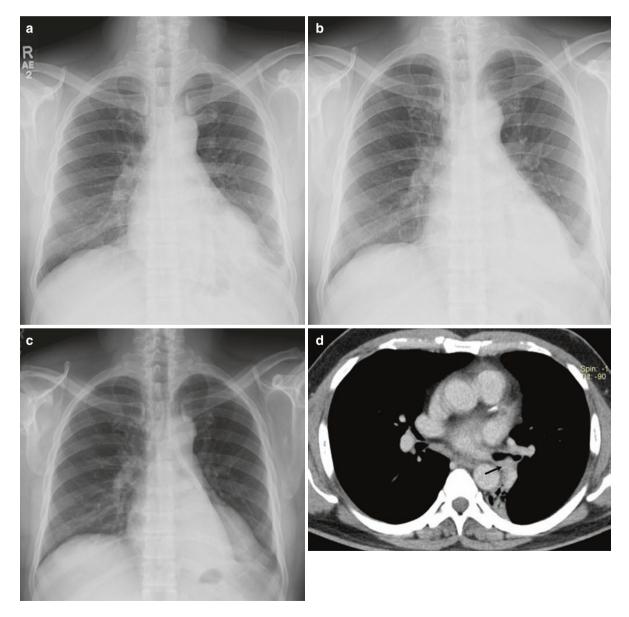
A 50-year-old man with carcinoid tumor. (a) Baseline normal radiograph performed 1 year back. Progressive left lobar lobe collapse at the time of presentation (b) and 5 days later (c). (d) Axial CT image shows a small endobronchial nodule (arrow) with left lower lobe collapse
